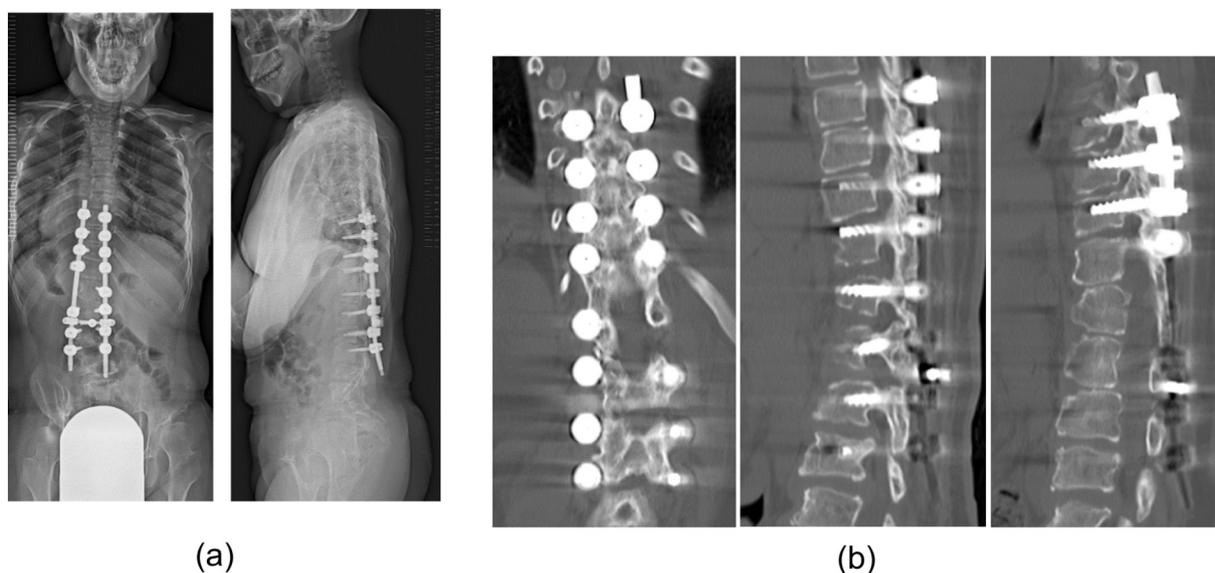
(a) The pedicle screws in L4 backed out and lumbar lordosis became slightly decreased. (b) Postoperative computed tomography shows achievement of bone union 3 years after surgery.
